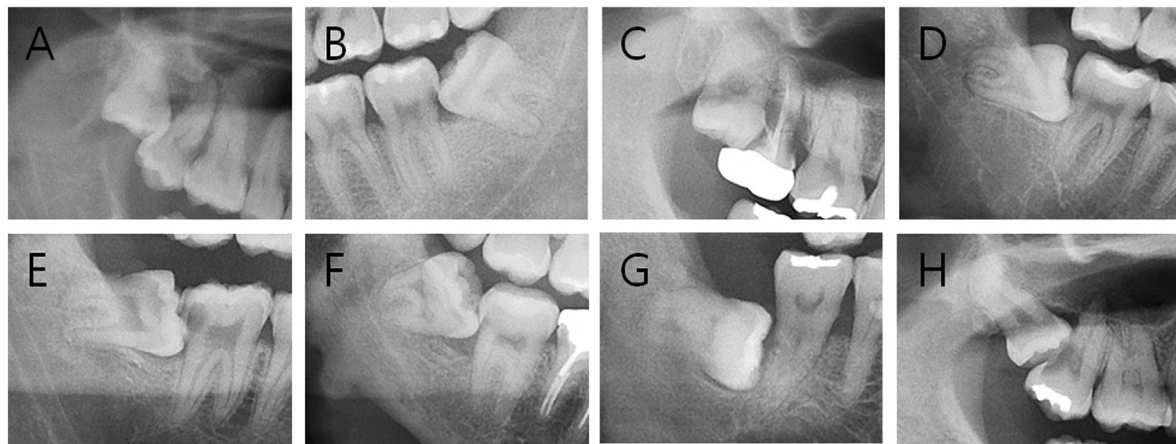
The radiographic features of damage types to adjacent teeth (second molars) due to untreated ITMs. All figures were cropped from the patients' panoramic radiographs. (A) Distal bone loss. (B) Dental caries that needed conservative treatment without the need for endodontic treatment or extraction. (C) Extraction of adjacent second molars. (D) Caries without treatment. (E) Endodontic treatment due to severe dental caries or apical involvement of cystic lesions in ITMs. (F) Distal bone loss with dental caries treatment (A+B). (G) Distal bone loss with dental caries, however, without the need for conservative treatment (A+D). (H) Distal bone loss with endodontic treatment (A+E).
